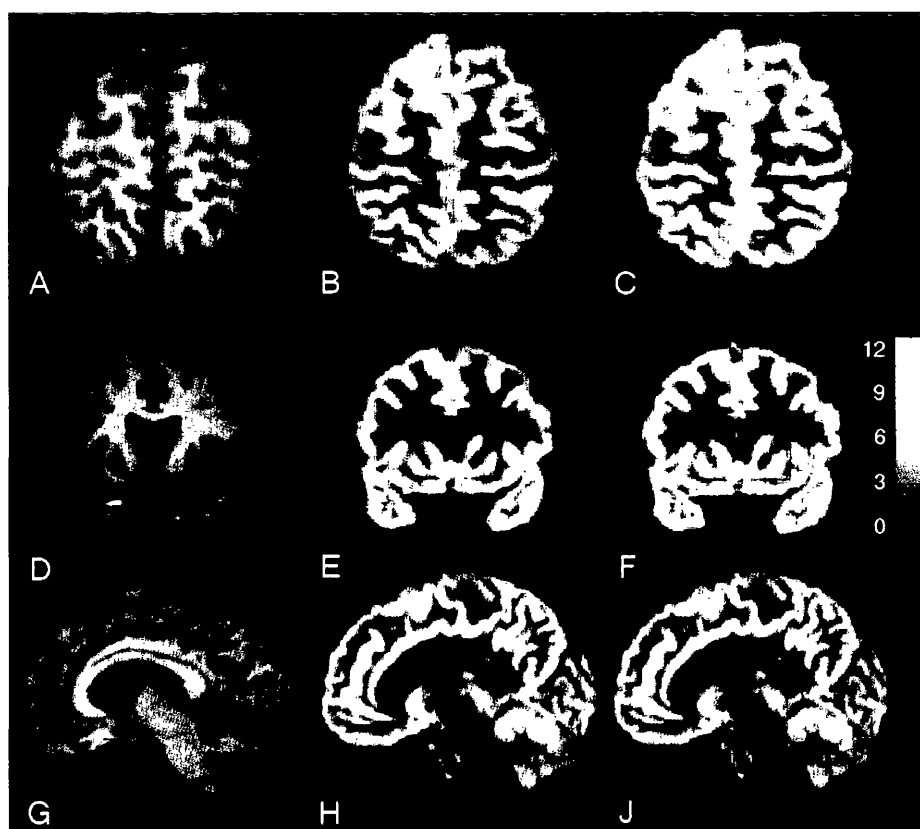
Patient 43, patient with left frontal lobe epilepsy and normal conventional MRI.
